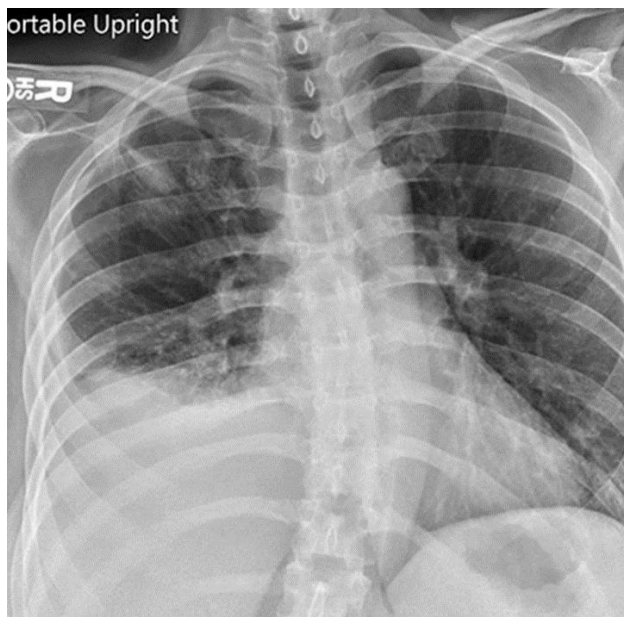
Frontal chest radiography obtained several weeks after the ¹⁸FDG-PET scan.
